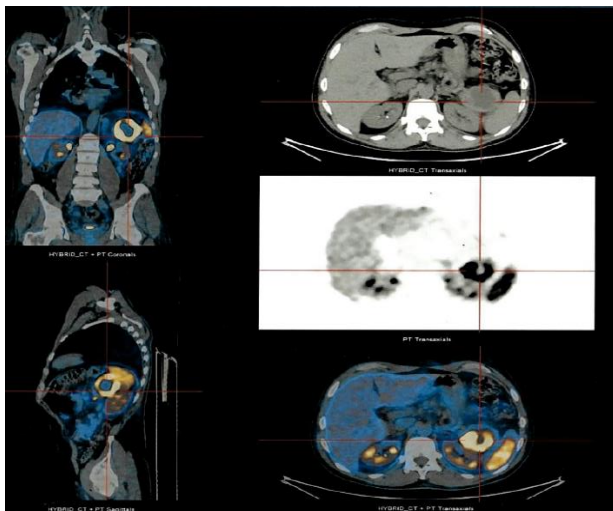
⁶⁸Ga-DOTA-NOC PET/CT showing a bigger nodular structure in pancreatic tail (60×45 mm), also overexpressing somatostatin receptors.
